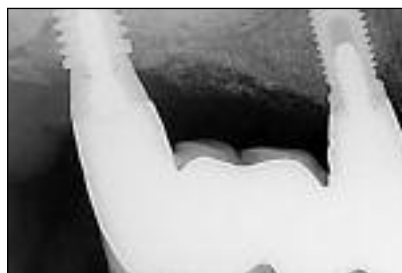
Standardized radiograph at the time of insertion of the definitive prosthesis demonstrating test and control implants in one patient.
